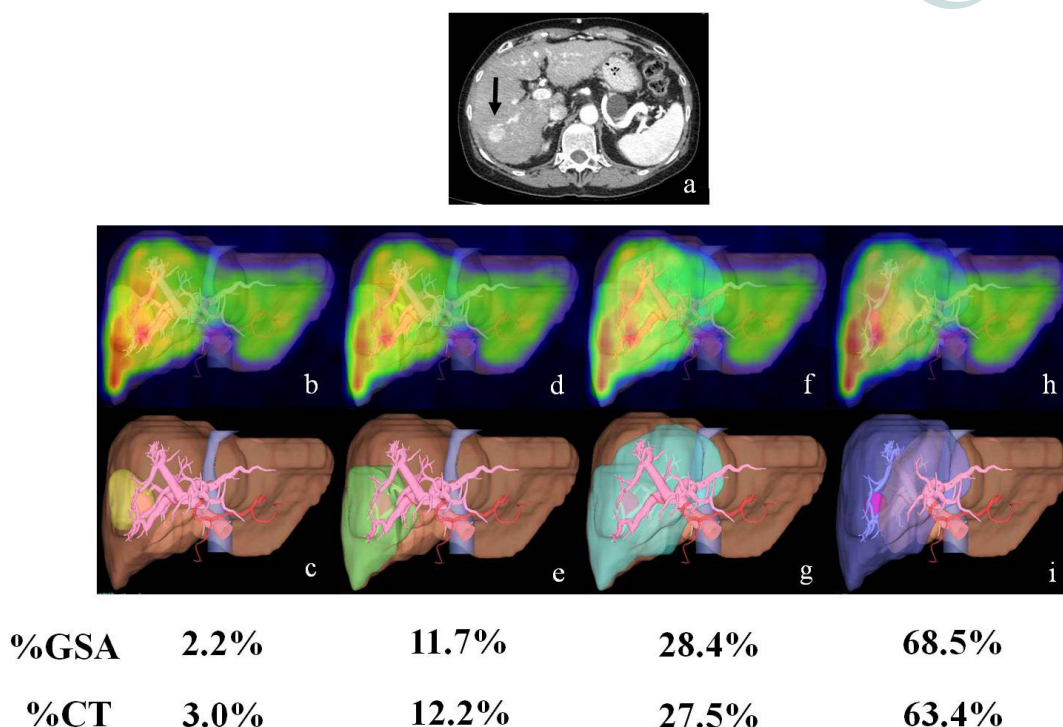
Various patterns of % GSA and % CT on 3D-99mTc-GSA scintigraphy/vascular fusion images in case 11. (a) CT image (planned resection region); (b) partial hepatectomy; (c) partial hepatectomy; (d) segmentectomy (S6); (e) segmentectomy (S6); (f) right lateral sectionectomy; (g) right lateral sectionectomy; (h) right hepatectomy on 3D-99mTc-GSA scintigraphic image; (i) right hepatectomy on 3D-vascular image. % CT: conventional volume ratio of planned resection region without tumor; % GSA: functional volume ratio of planned resection region without tumor
